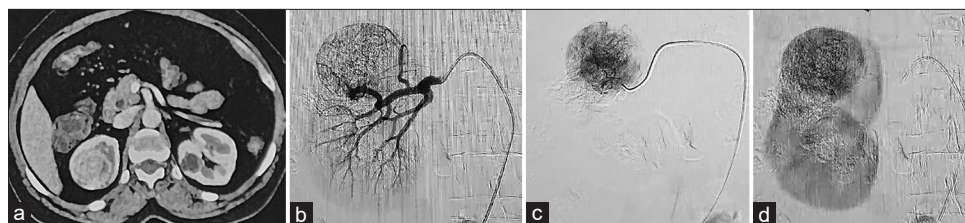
(a) Contrast computed tomography scan axial image showing the right upper pole mass which is entirely endophytic (b) Preoperative digital subtraction angiogram image showing the tumor being supplied through two upper pole arterial branches (c) Indocyanine and Ethiodized Oil mixture was injected superselectively into the branch vessels supplying directly to the tumor (d) Postinjection run of the main renal artery showing Ethiodized Oil deposition in the upper pole mass, whereas the rest of kidney shows normal nephrogram
